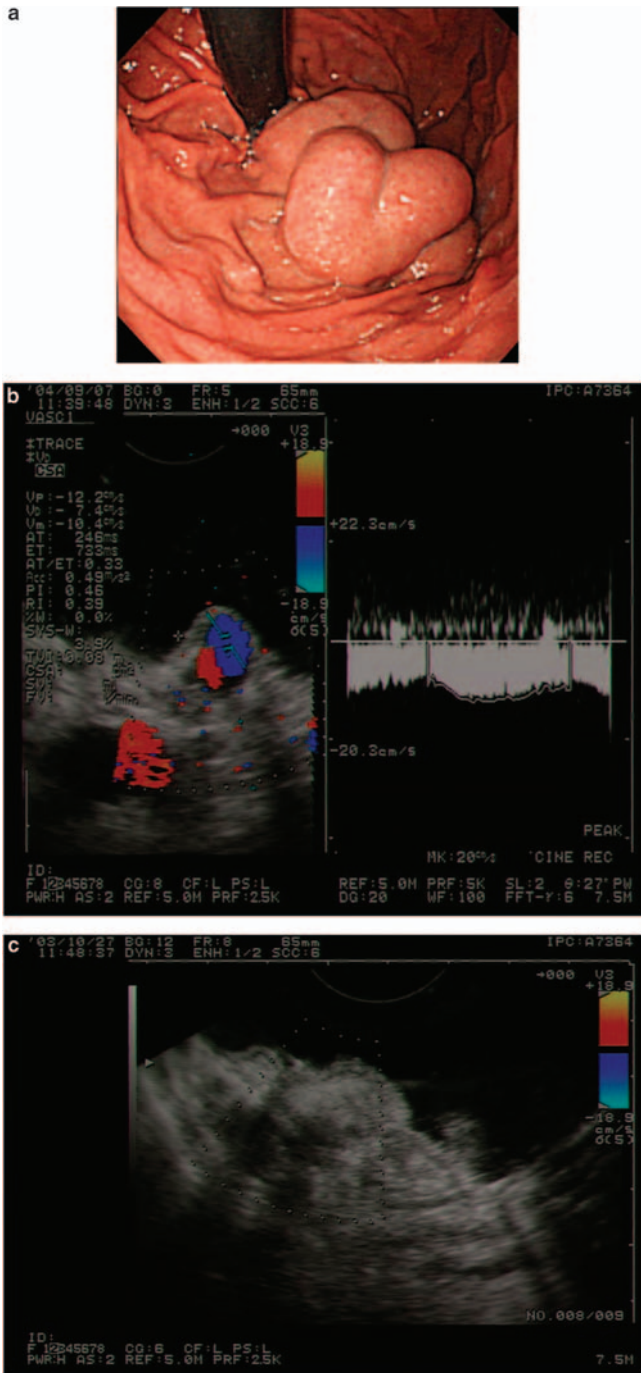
A typical case of gastric varices (GV) included in the present study. (a) Endoscopic appearance of GV; Lg-cf, F3, Cw, RC (-). (b) Hemodynamic parameters of gastric varices assessed by ECDUS before B-RTO. V_p , peak systolic velocity; V_d , end diastolic velocity; V_m , mean velocity; R_i , resistance index. (c) ECDUS revealed no flow, suggesting complete obliteration of GV after B-RTO. B-RTO, balloon-occluded retrograde transvenous obliteration; ECDUS, endoscopic color Doppler ultrasonography.
